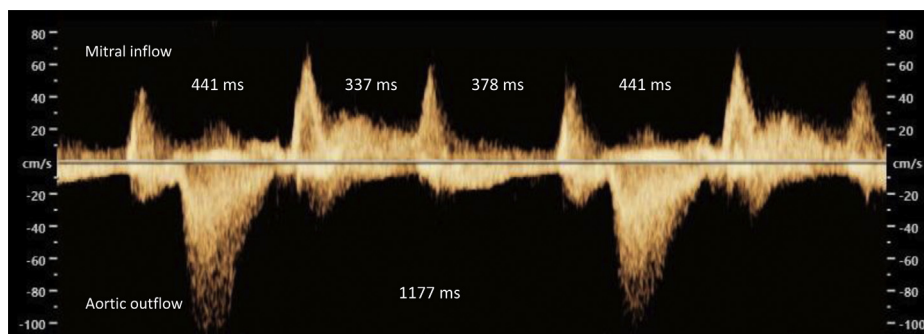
Fetal Doppler showing type 2 second-degree atrioventricular (AV) block with 3:1 AV conduction at 37 5/7 weeks. Spectral Doppler of mitral inflow (above baseline) and aortic outflow (below baseline). These tracings were 1 week later than those shown in Figure 1. Variability in atrial cycle length (top row of numbers) is similar to that shown in Figure 1. Ventricular cycle length is 1177 ms (bottom row of numbers).
